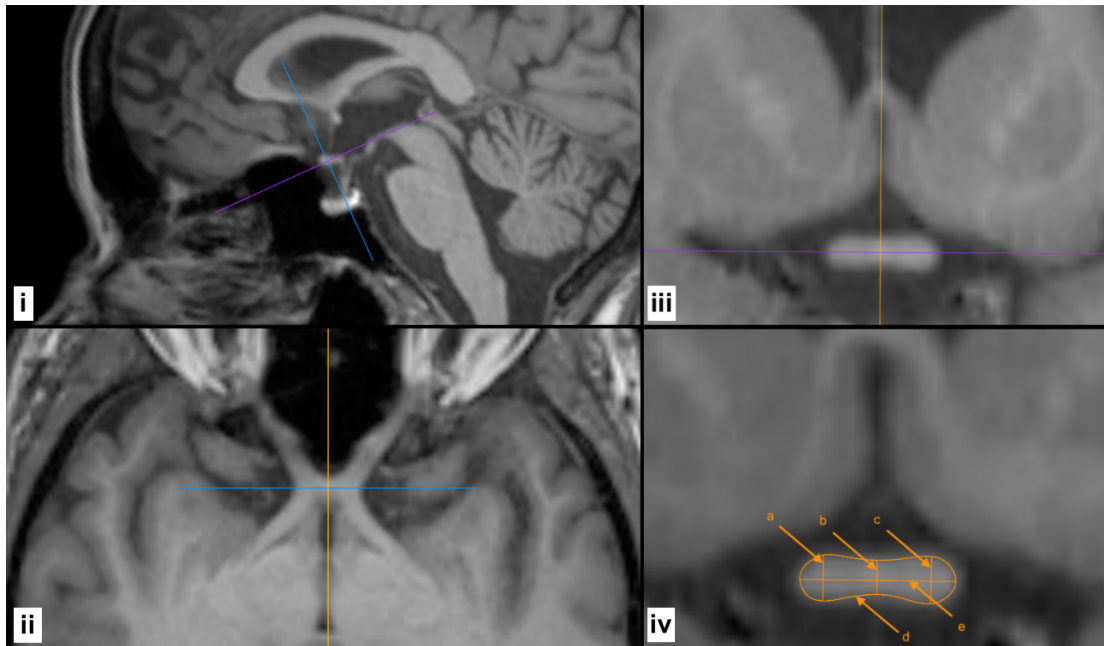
Adjustment of axis for optic chiasm MRI measurements.
